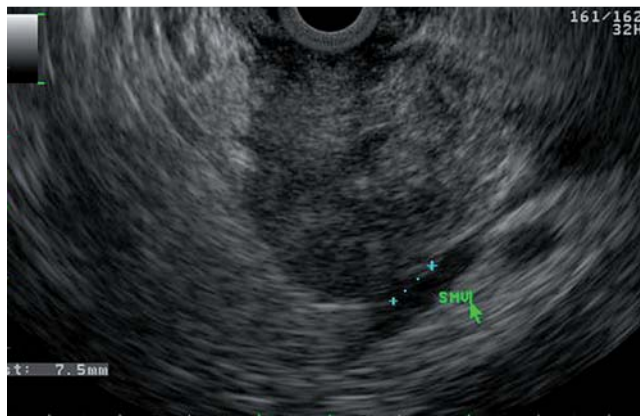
Endoscopic ultrasound showing a heterogeneous, hypoechoic pancreatic head mass in close proximity to the superior mesenteric vein (SMV).
